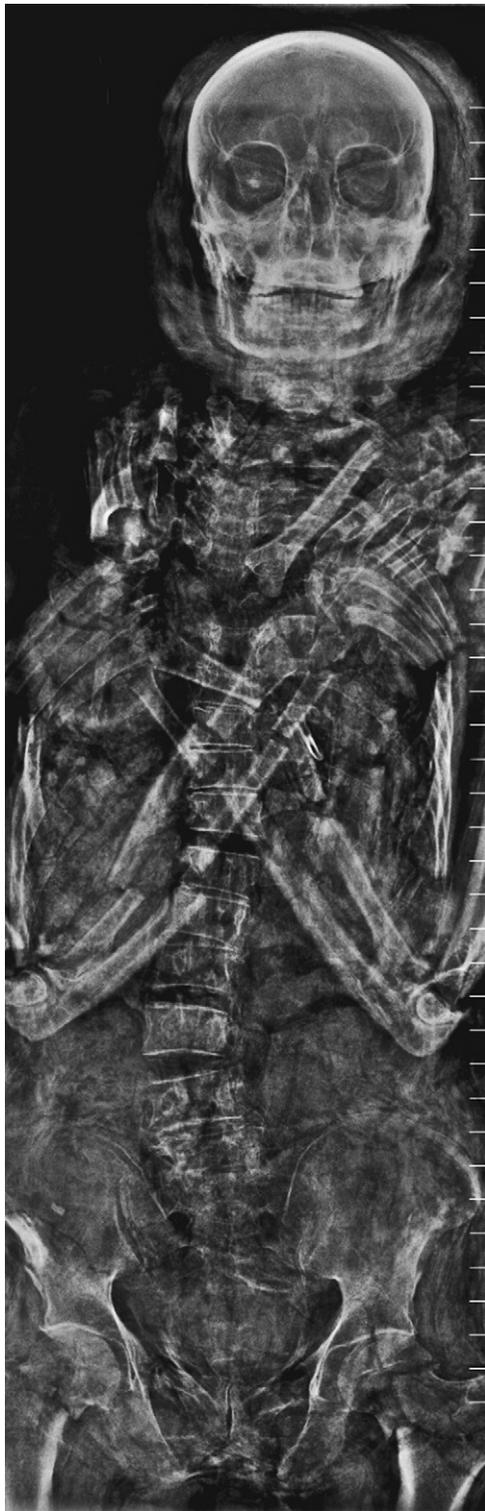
X-ray digital extended-view of the upper body, showing the crossed arms mummification position and extensive post-mortem bone fractures.
